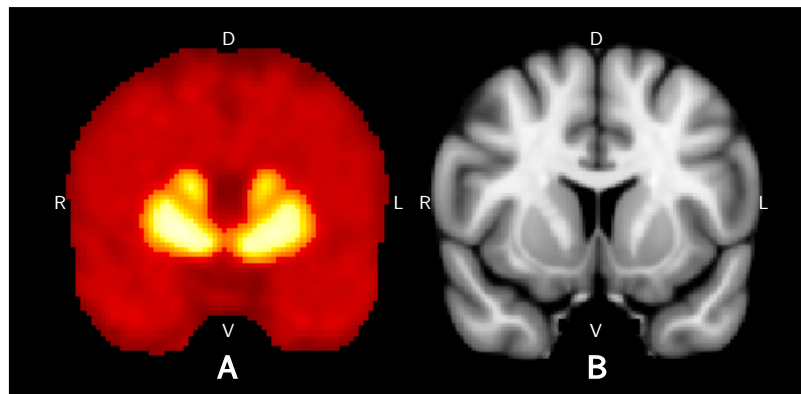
A) PET and B) structural MRI images. R=right; L=left; D=dorsal; V=ventral.
